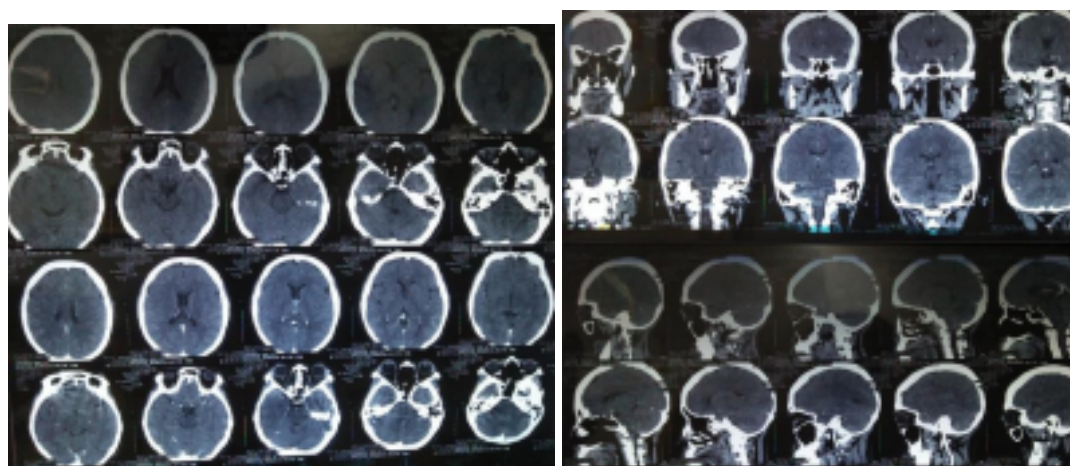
Head MRI on presentation
